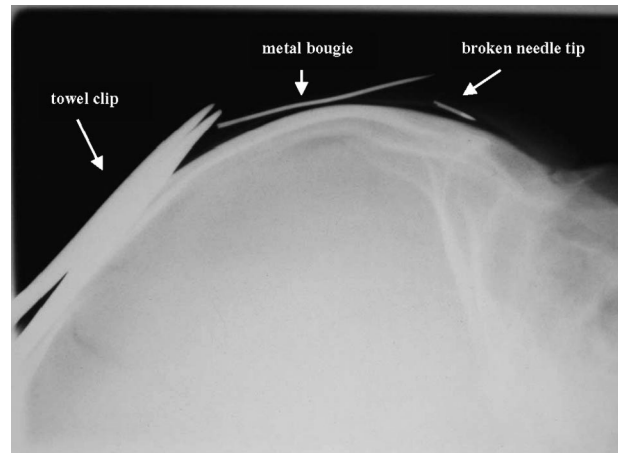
Radiograph of broken needle tip in situ. Metal bougie was used as a marker.
